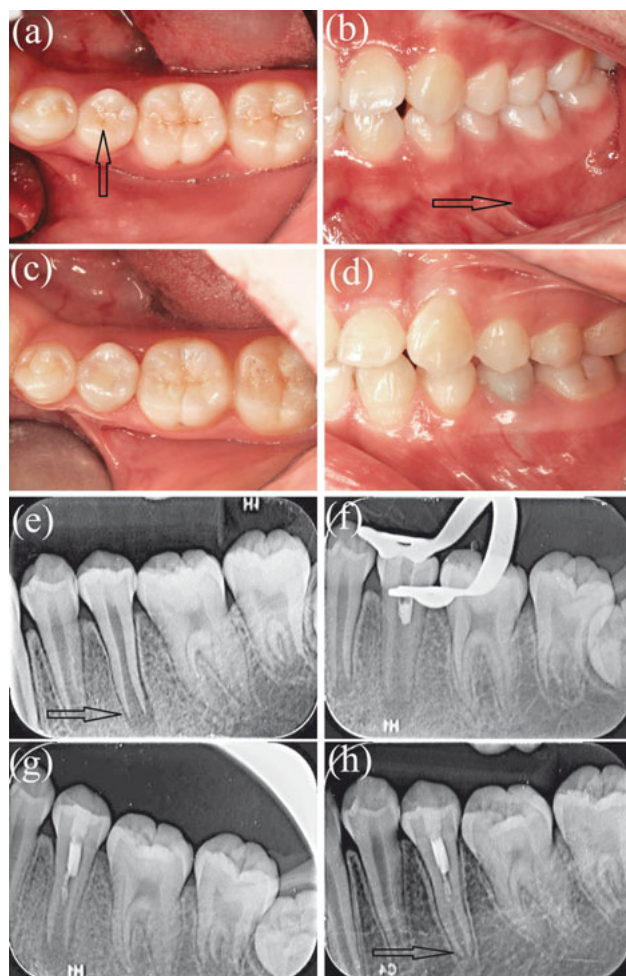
Case 1 intraoral photographs and periapical radiographs. a) Pre-treatment occlusal photograph of the mandibular left second premolar (tooth 35) with dens evaginatus and a fractured occlusal tubercle (arrow); b) pre-treatment intraoral photograph of tooth 35, showing swelling and redness on the buccal mucosa (arrow); c) occlusal photograph at the 8-month follow-up; d) intraoral photograph at the 8-month follow-up; e) pre-treatment periapical radiograph of tooth 35 showing the periapical radiolucency and immature root (arrow); f) periapical radiograph taken during iRoot BP placement; g) periapical radiograph taken after completion of the iRoot BP filling at the first treatment visit; h) periapical radiograph taken at the 8-month follow-up; the root canal was lengthened, the root wall had thickened and the apical foramen had narrowed (arrow).
